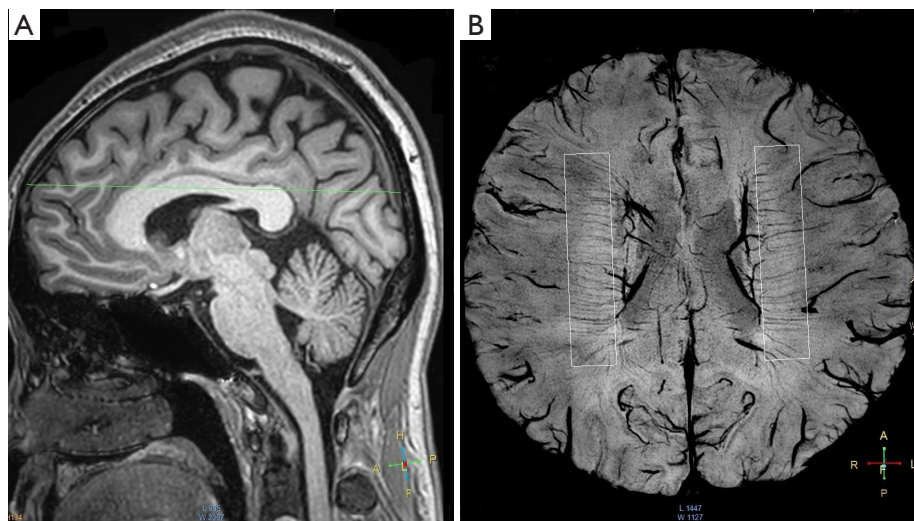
An example of SWI-based assessment of DMV counts in a 32-year-old male. SWI showing normal DMVs. (A) Loss-of-position selection of a 6-mm-thick section parallel to the corpus callosum. (B) Minimum-intensity projection of SWI and DMV count ROI on 3-T MRI. The white rectangular frames represent the ROI placed in the periventricular white matter in each cerebral hemisphere. The DMV count of the patient was 20. SWI, susceptibility-weighted imaging; DMV, deep medullary vein; ROI, region of interest; MRI, magnetic resonance imaging.
